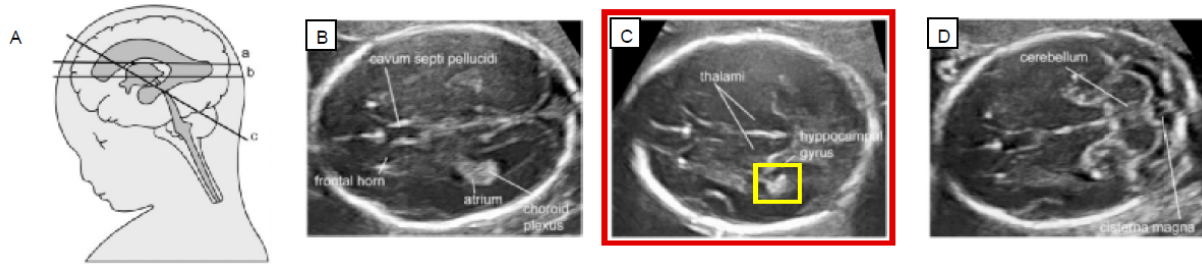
Three axial ultrasound planes used in standard fetal neurosonography examination (A): transventricular plane (B), transthalamic plane with yellow box around the choroid plexus(C), transcerebellar place (D). (Adapted from [3])
